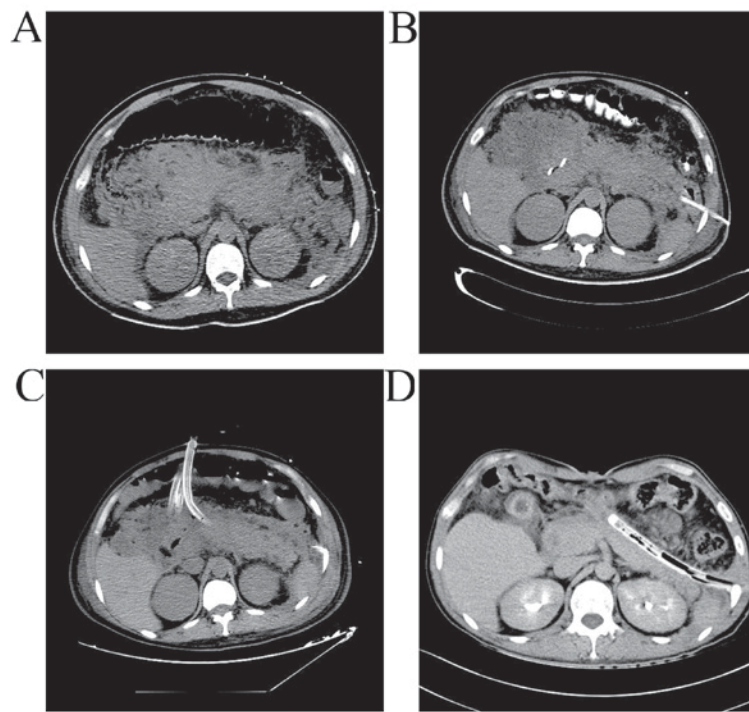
Representative CT of patients receiving PCD followed by PN. (A) The pancreas exhibited marked edematous and heterogeneous enhancement with indistinct margins due to a large number of acute peripancreatic fluid collection. (B) CT-guided percutaneous transperitoneal drainage was performed and a 16 Fr pigtail catheter was placed in the left lower abdomen. (C) The first minimal incision and video-assisted laparoscopic debridement. A 30-32 Fr three-cavity drainage tube was placed in the head, body and tail of the pancreas. (D) Multiple drainage and debridement resulting in a marked reduction with distinct margins of peripancreatic fluid collection. CT, computed tomography; Fr, French gauge; PCD, percutaneous catheter drainage; NP, necrotizing pancreatitis.
